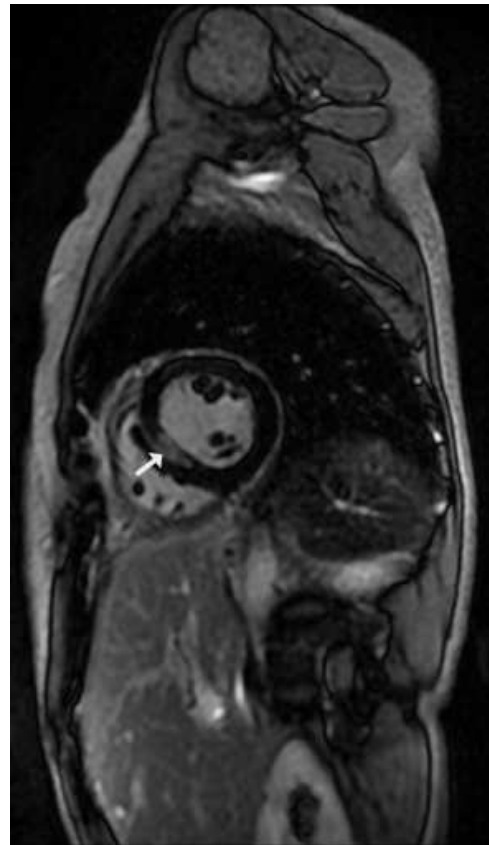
Late Gadolinium Enhancement MRI showing pericardial inflammation
